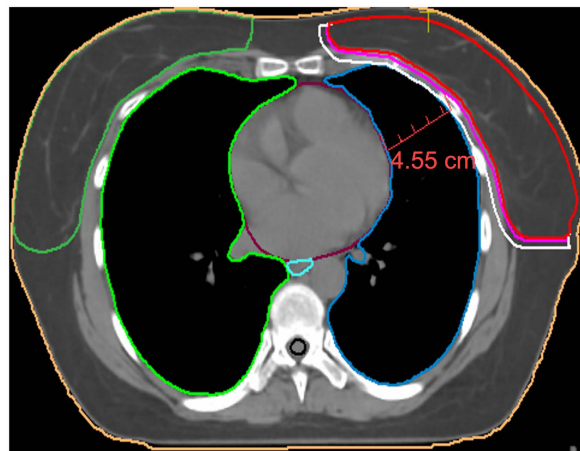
A computed tomography scan image showing a transversal plane displaying the heart position and the organs at risk acquired during DIBH technique.
